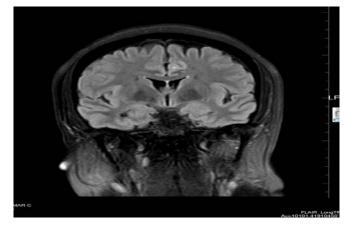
MRI Brain showing FAIR Hyperintensities in cortical region involving cingulate gyrus.
